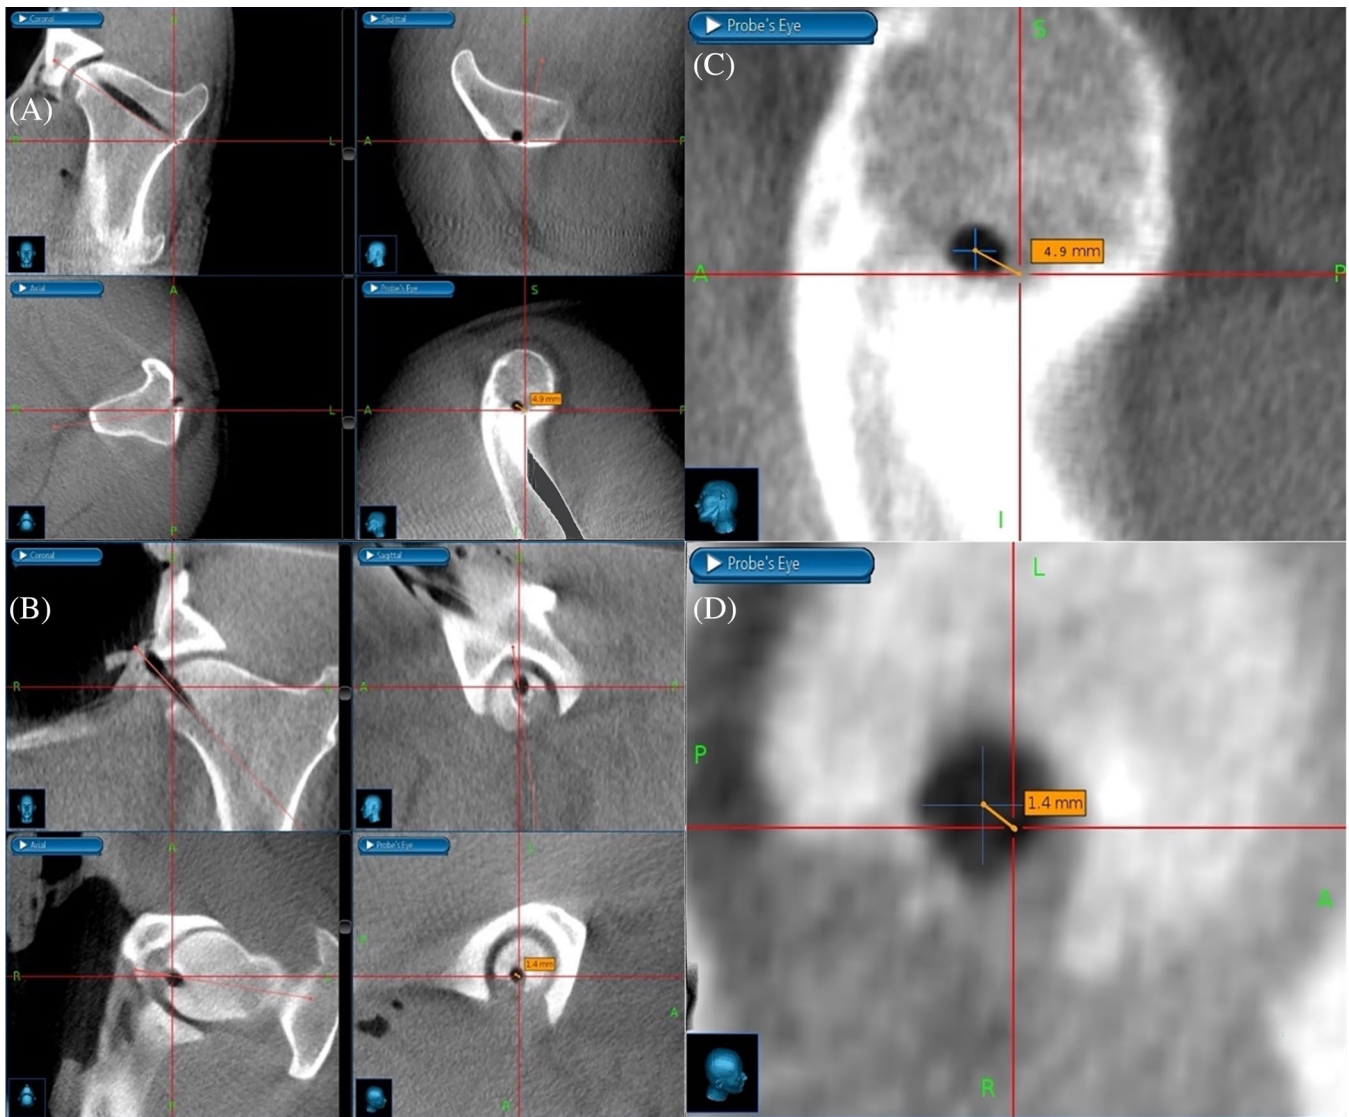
Screenshots of the multiplanar reconstructions of the merged pre- and postoperative cone beam computed tomographic scans used to measure the surgical accuracy aberrations (SAA) of pony 1. Images (C, D) are the magnified versions of the “probe’s eye” images visible in the bottom right corner of (A, B), respectively. The center of the red crosshairs marks the axis of the surgical plan in each depicted plane. The SAA at the femoral entry site (A, C; 4.9 mm) and the exit site at the fovea capitis (B, D; 1.4 mm) are determined by measuring the distance between the center of the drilled bone canal and that of the planned drill corridor (center of the red crosshairs) in the “probe’s eye” planar reconstruction of the Cranial Software (Medtronic). The “probe’s eye” view shows a plane that is perpendicular to the trajectory of the planned drill corridor, in this study a slightly proximolateral-distomedial oblique sagittal plane of the femur.
